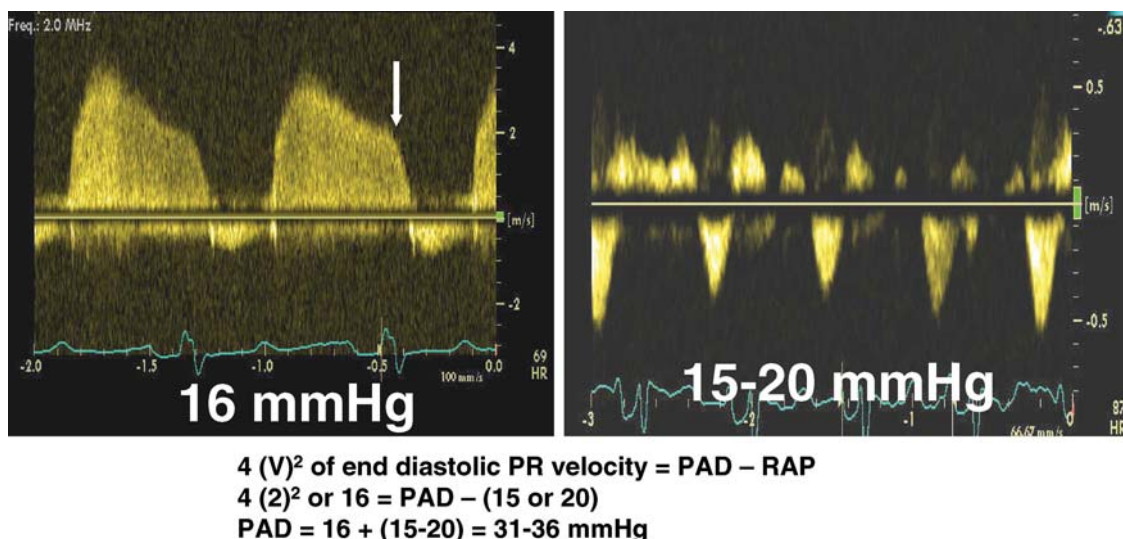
Calculation of PA diastolic pressure using the PR jet (*left*) and hepatic venous by PW Doppler (*right*). In this patient, the PR end-diastolic velocity was 2 m/s (*arrow*), and RA pressure was estimated at 15 to 20 mm Hg (see Quiñones et al¹⁹ for details on estimating mean RA pressure).
